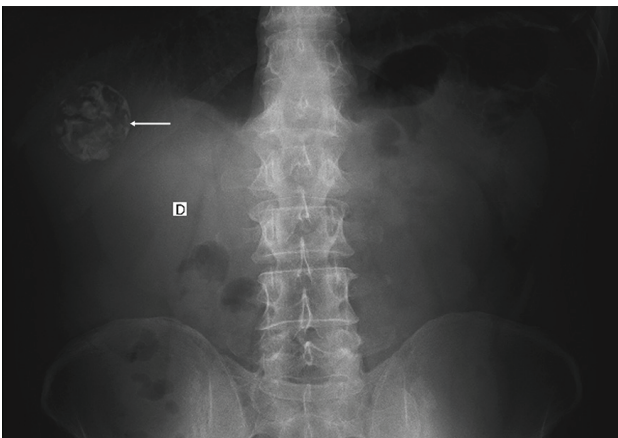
Abdominal x-ray taken in a standing position in the same patient as in Figure 11 shows a radiopaque oval lesion in the right upper quadrant (arrow). Gharbi V-CE5.
